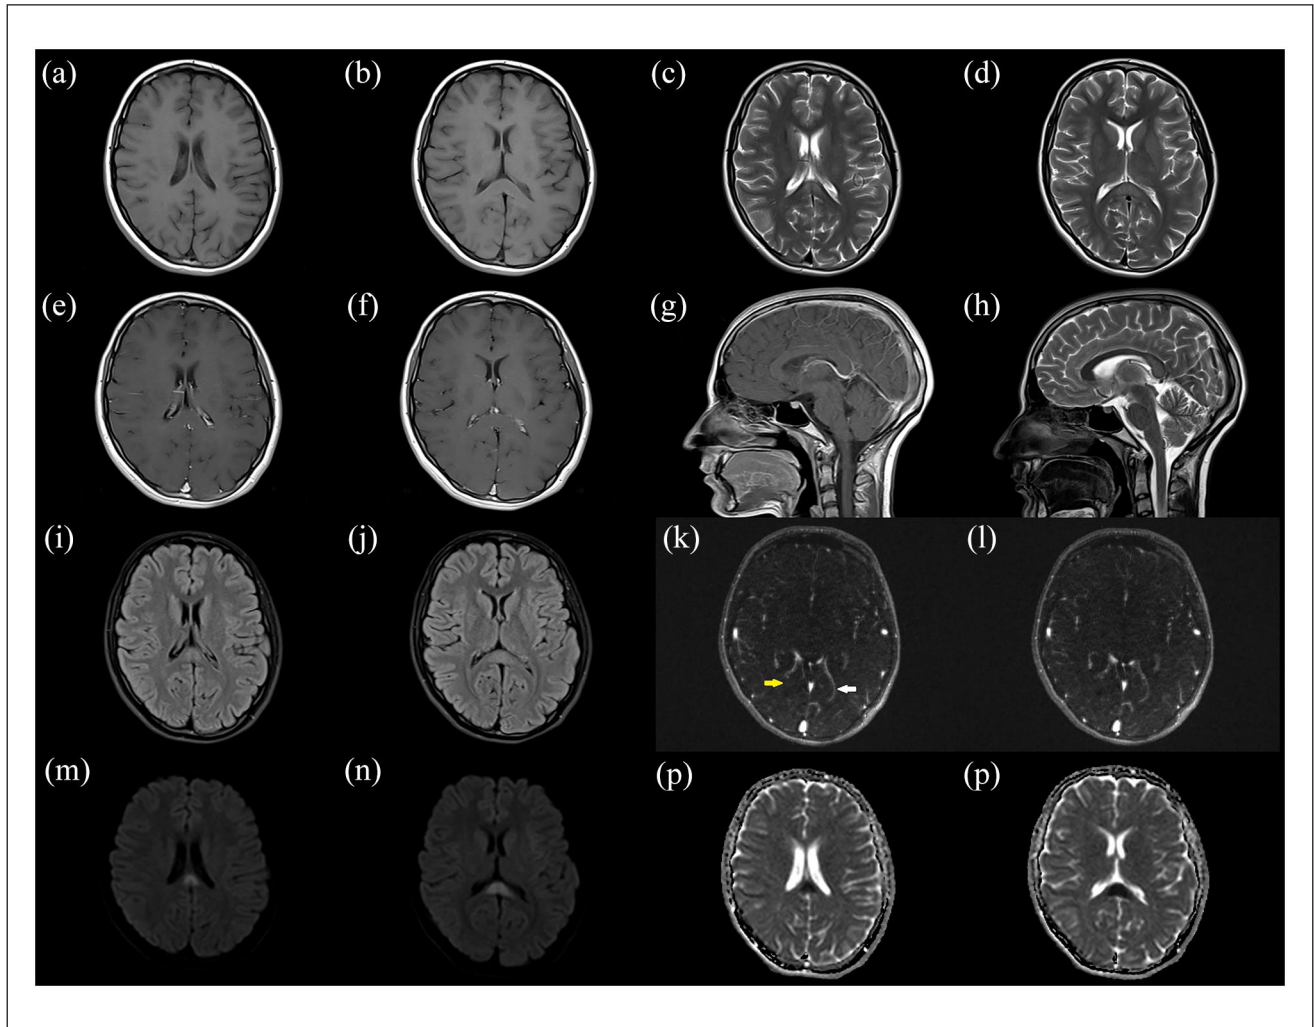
Magnetic resonance (MR) images of Case 1 (19-year-old female with isolated splenium infarct after COVID-19 infection). There is a slightly hypodense area in the location of splenium in T1-weighted images ((a) and (b)) and hyperintensity in the same location on axial T2-weighted images. There was no contrast medium enhancement in splenium on T1-weighted axial ((e) and (f)) and sagittal (g) series. T2-weighted sagittal image indicated the lesion in splenium with high signal intensity as well as axial FLAIR images ((i) and (j)). MR angiography shows the discontinuity of the right posterior cerebral artery on consecutive axial images ((k) and (l)). Diffusion-weighted images depict the diffusion restriction of splenium ((m) and (n)) with apparent diffusion coefficient maps ((o) and (p)).
